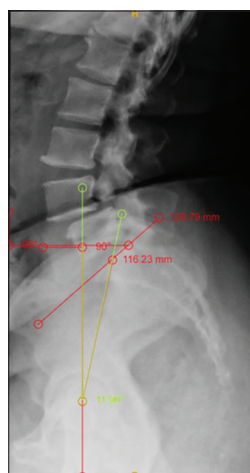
Measurement of slip angle on the lateral radiograph. Measure the angle between the lines drawn along the inferior end plate of L4 and the superior endplate of the L5 vertebra
